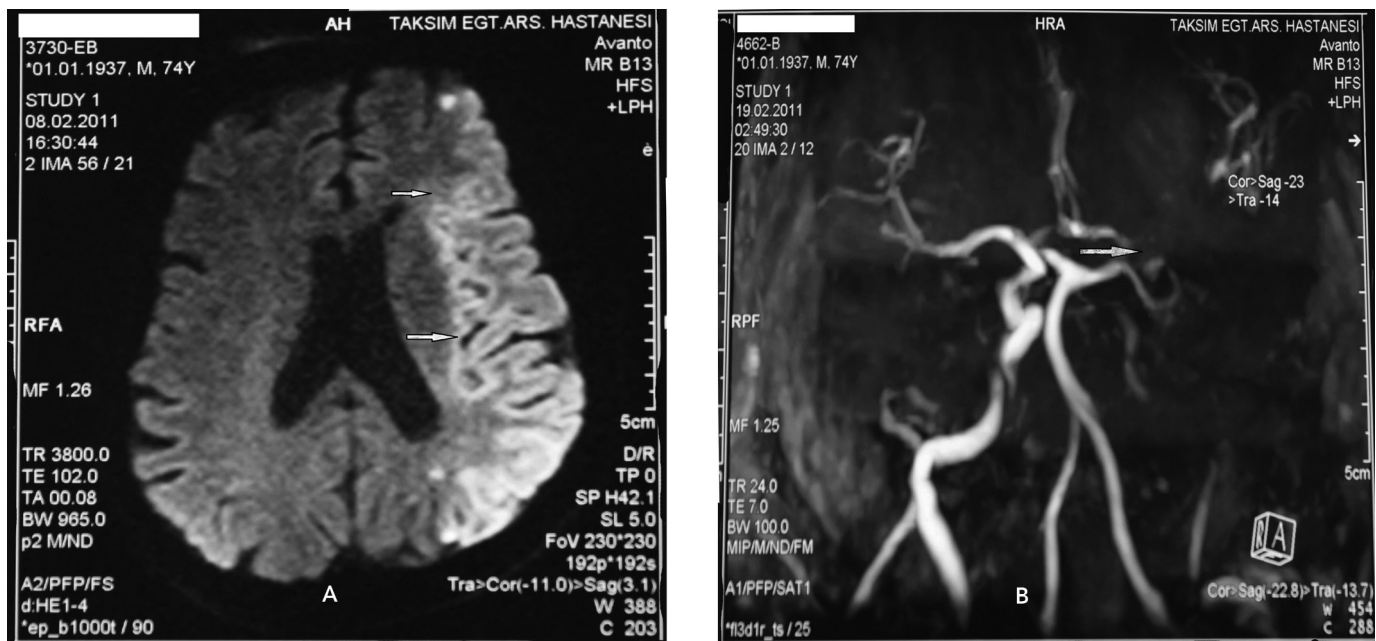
A) A 74-year-old patient presenting with motor aphasia and right hemiplegia has diffuse left middle cerebral artery infarction (a combination of perforating artery infarction, pial artery infarction, border-zone infarction patterns) on diffusion-weighted magnetic resonance imaging. B) There is a 70% stenosis in the left middle cerebral artery on magnetic resonance angiography of the same patient
